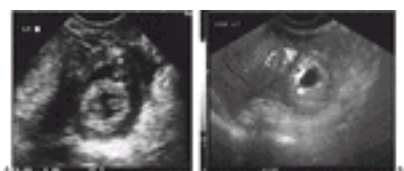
Ectopic pregnancy. A: Unruptured ectopic pregnancy appearing as a “tubal ring” in left adnexa. B: Transvaginal color Doppler sonogram showing vascularity of “tubal ring” of an unruptured ectopic pregnancy. See [color figure 28.9](#).
